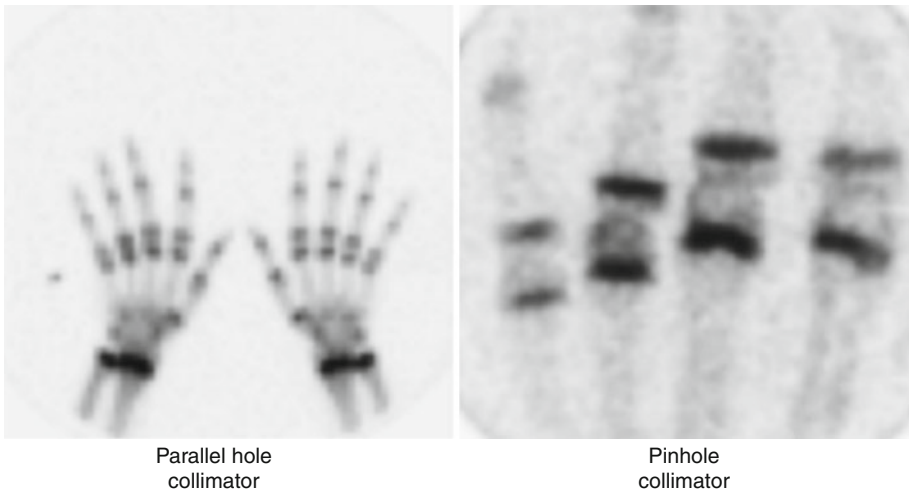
A 10-year-old male with 2 months of pain and swelling in the region of the fourth left metacarpal phalangeal joint. The x-rays, CBC, and ESR were normal. The clinical question was osteomyelitis versus soft
